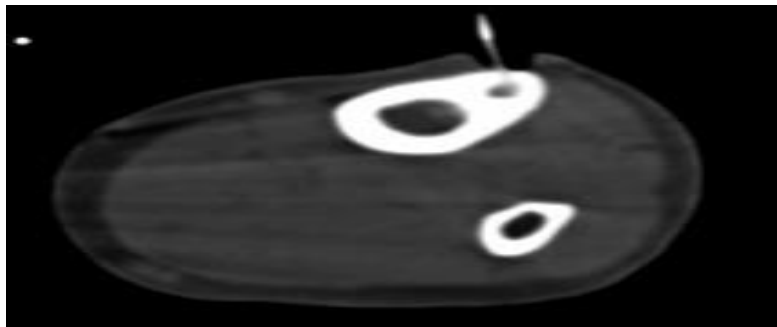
Case 4 Male, 32 years old, osteoid osteoma of proximal tibia, 2016-4-20, intraoperative CT localization.
